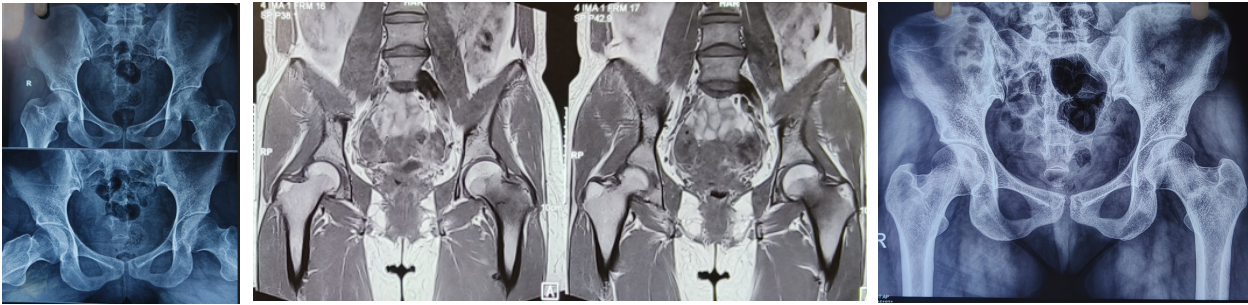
Stress fracture of neck of femur that has been managed conservatively (X-ray and MRI image (above) and Xray after healing of fracture (below)).
